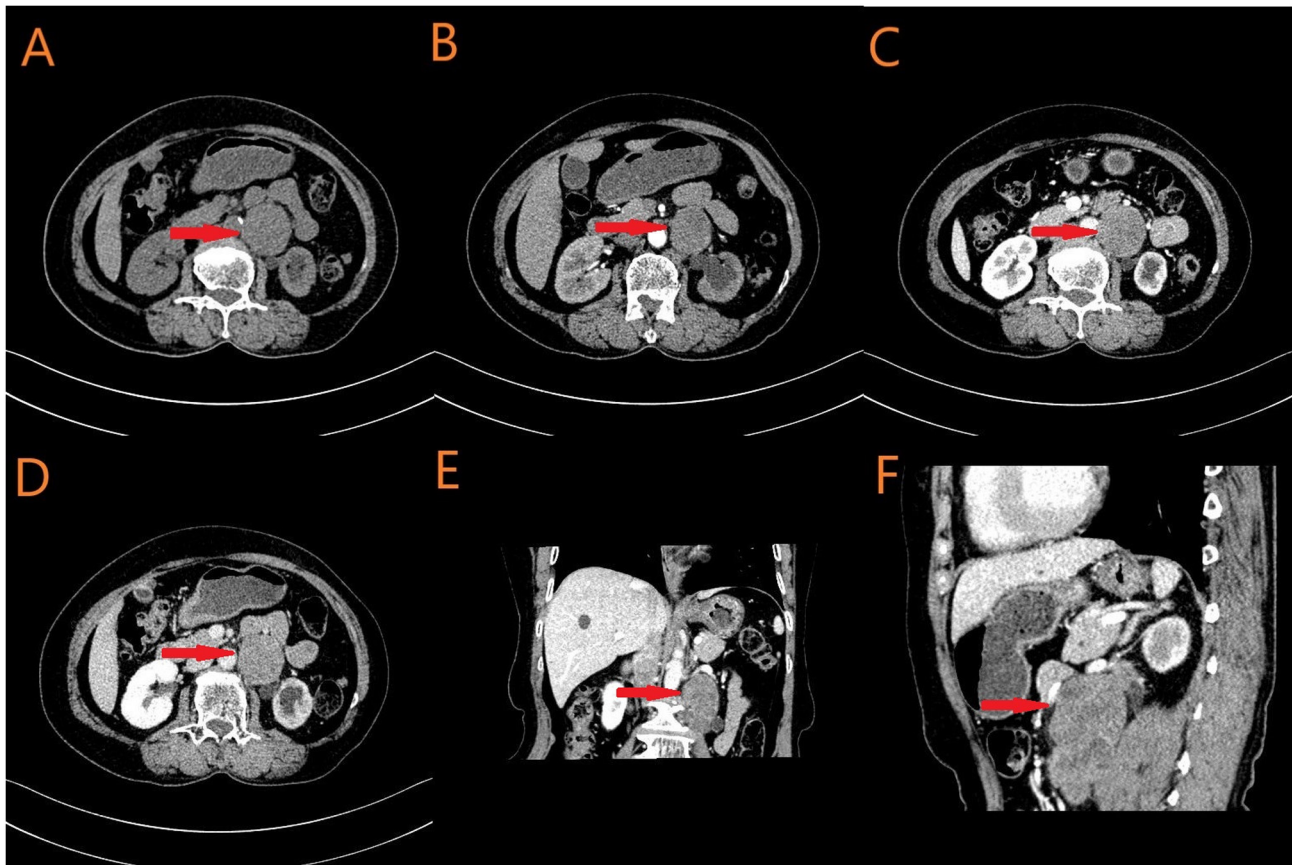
Abdominal CT images. (A) Plain phase, (B) arterial phase, (C) venous phase, (D) excretory phase, (E) venous phase coronal and (F) venous phase sagittal images.
